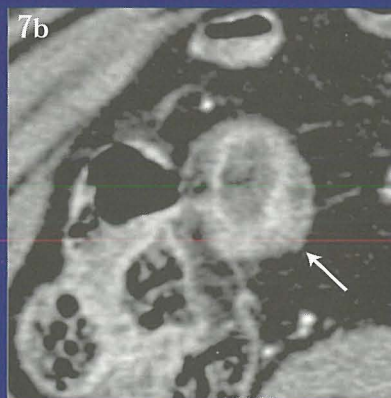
Early Crohn's disease. (a) Image from a small bowel follow-through study shows mild nodularity in the terminal ileum (arrows). (b) CT scan shows mild diffuse wall thickening and mucosal enhancement of the terminal ileum (arrow). (c) Capsule endoscopic image shows a small aphthous ulcer in the terminal ileum (circled).
